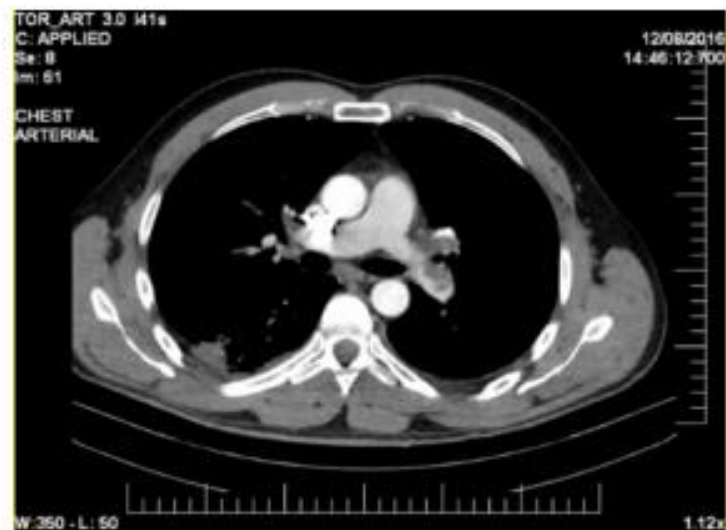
Thoracic CT angiography - left main pulmonary artery re-permeability
